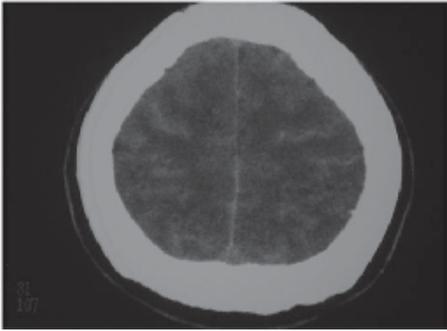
42-year-old Chinese male with headache. Unenhanced axial CT demonstrates blood in the subarachnoid space.
